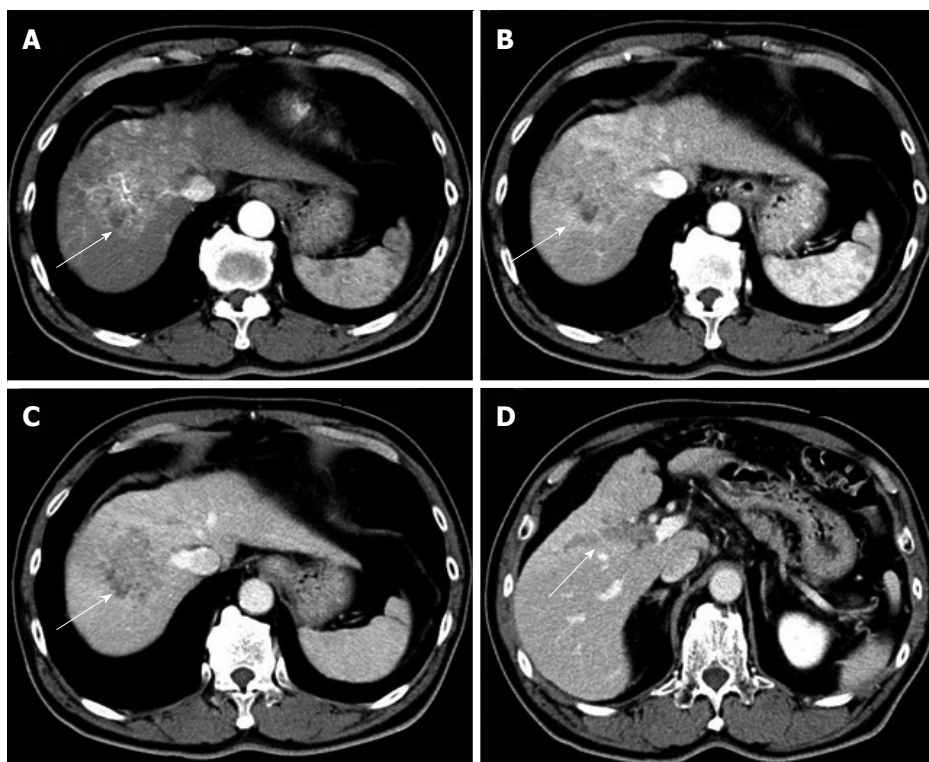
Contrast-enhanced computed tomography before sorafenib introduction. Heterogeneous hypervascularized tumor (A-C, arrow) in the right paramedian sector, showing early enhancement in the arterial phase and wash-out in the late phase together with portal vein tumor thrombosis (D, arrow) limited to the first-order branch and invading the right portal vein.
